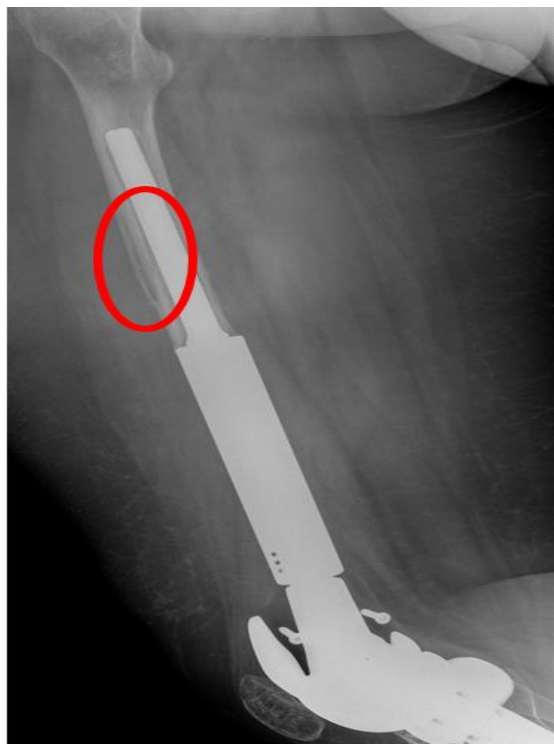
X-ray showing alteration in the structure compatible with signs of acute periostitis around the femoral prosthetic component (red circle)
